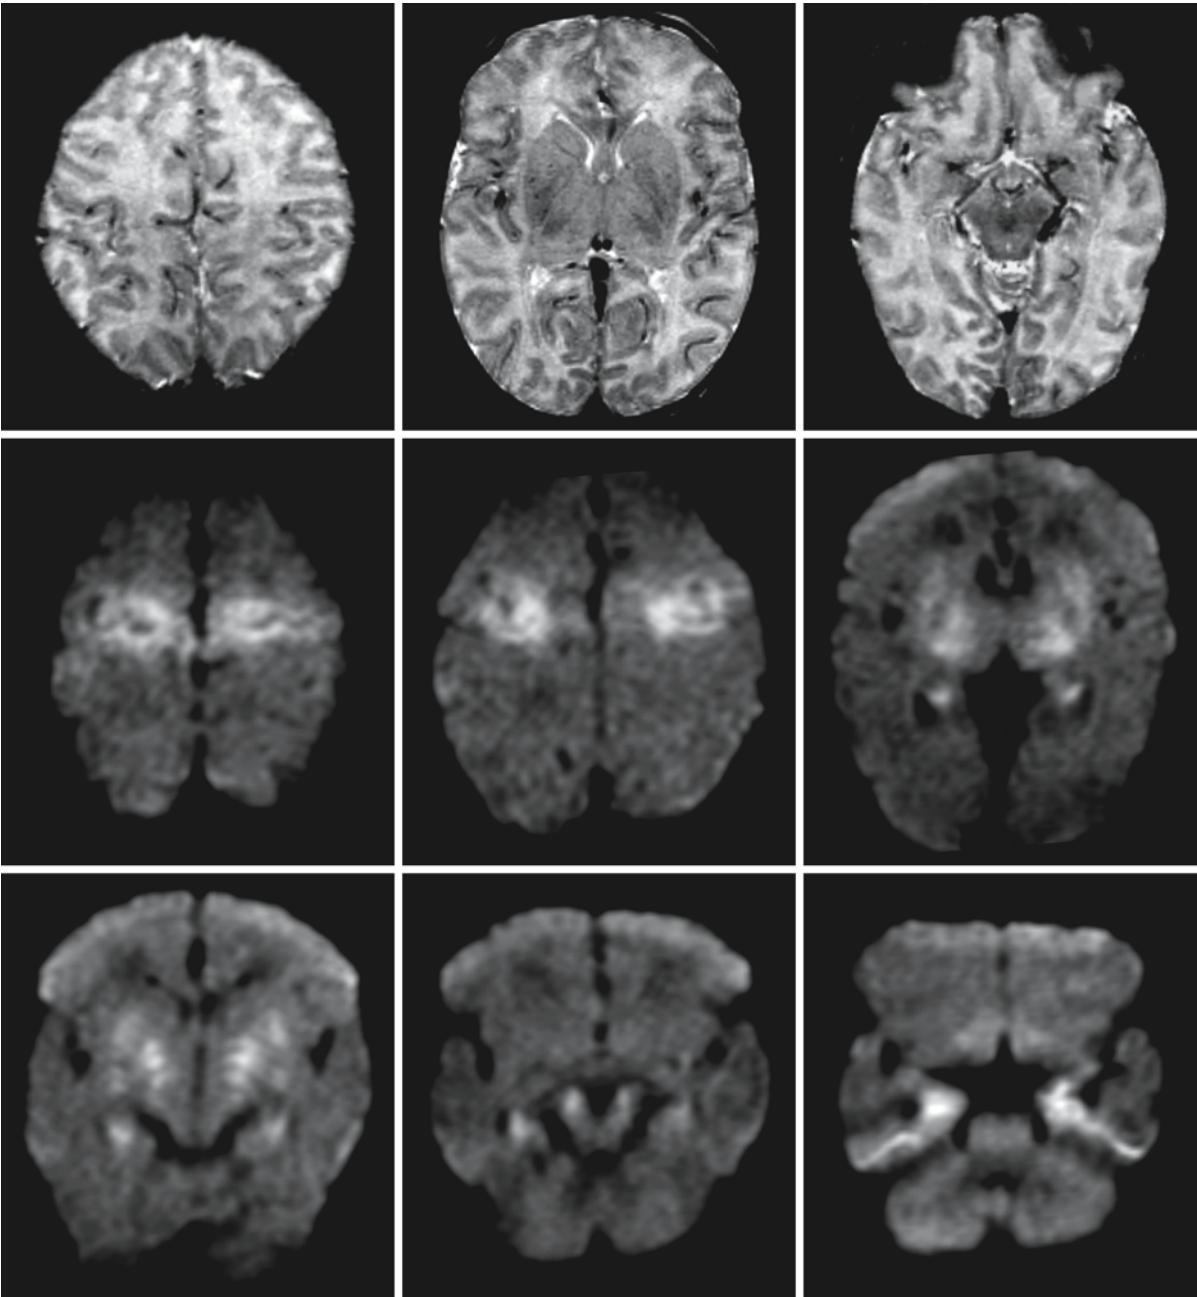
Images of a term-born neonate with acute profound hypoxia-ischemia. The *upper row* of conventional T₂-weighted images show generalized edema, including swollen and abnormal basal ganglia. The *lower two rows* of DWI-Trace
